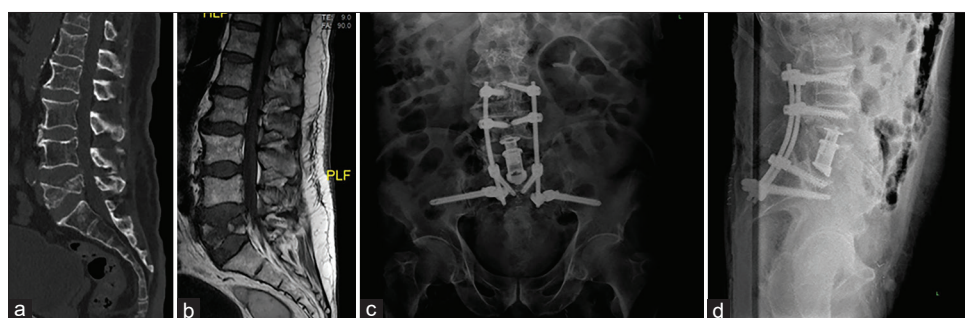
A 68 year old male patient followed up for multiple myeloma. L5 corpectomy and posterior instrumentation were performed on the patient due to severe low back pain and right L5 neurologic deficit. Patient's preoperative computed tomography (CT) scan image (a). Patient's preoperative magnetic resonance imaging (MRI) scan image (b). Patient's postoperative AP X-ray (c). Patient's postoperative lateral X-ray (d)
